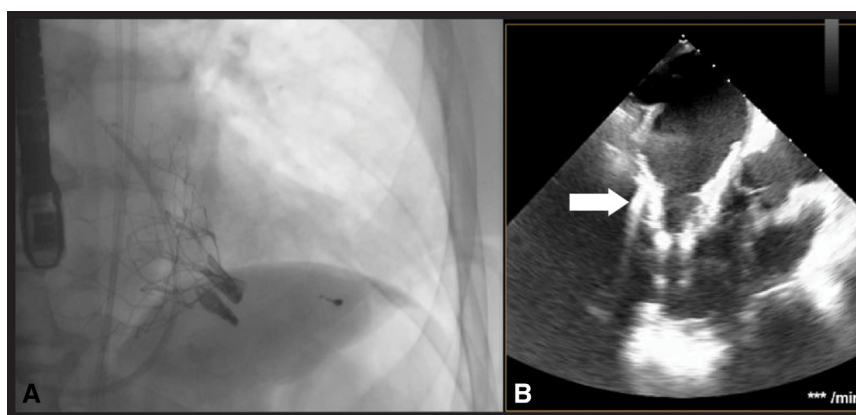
Final result of the modified transapical ELASTA CLIP procedure. Fluoroscopy (A) and transesophageal echocardiography (B) show the immobilized mitral clips (arrow) between the posterolateral ventricular wall and the Tendyne bioprosthesis.
